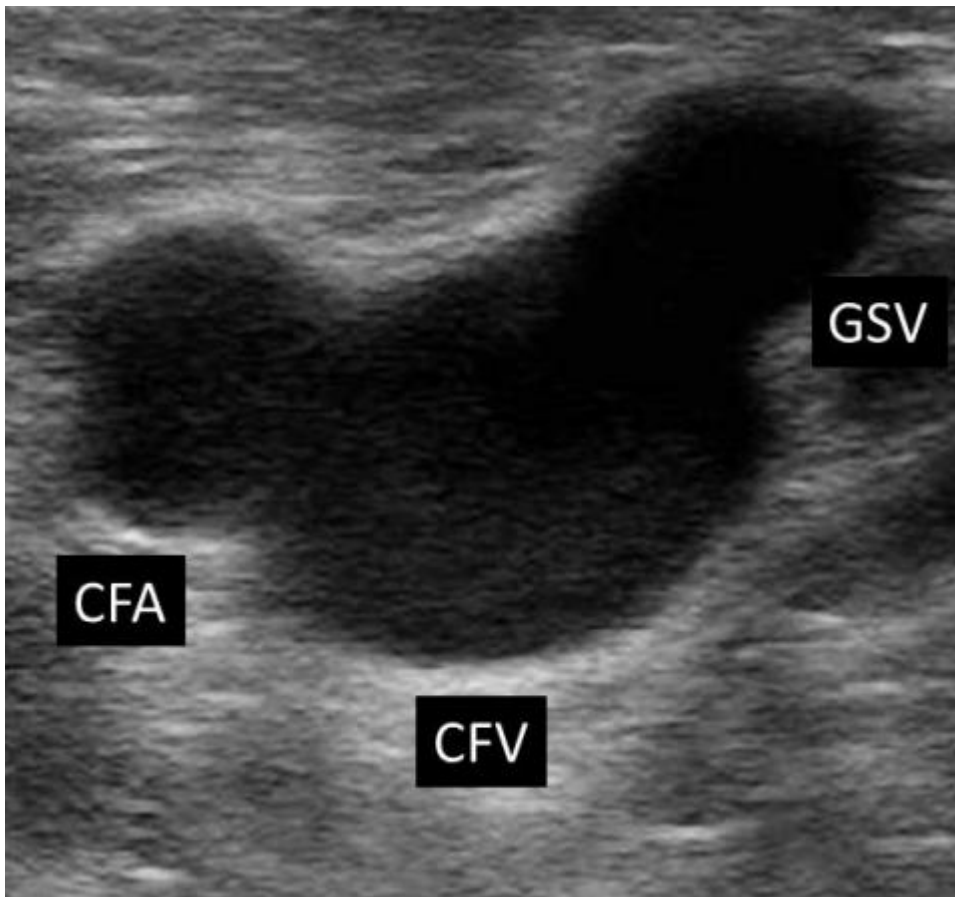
is the corresponding ultrasound image at this level.
